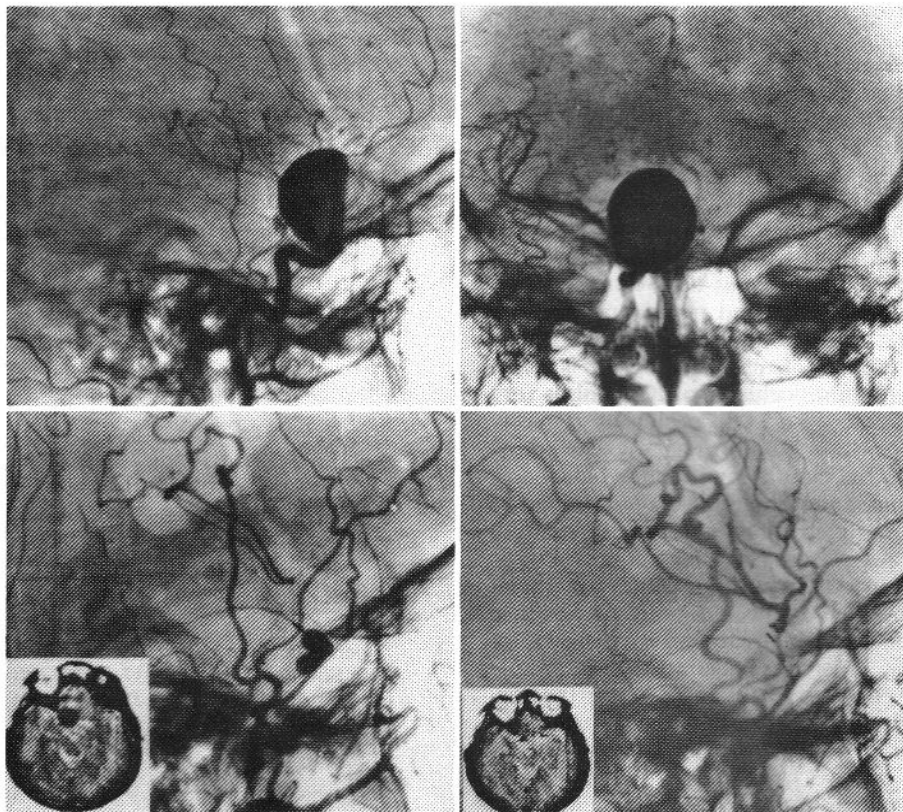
Case 2. *Upper Pair:* Angiograms before internal carotid artery occlusion and extracranial-intracranial bypass showing a giant partially thrombosed carotid-ophthalmic artery aneurysm. *Lower Left:* The size of the aneurysm is better appreciated on the computerized tomography (CT) scan (*inset*). The intraoperative angiographic control showed good bypass patency and no filling of the aneurysm. Note the balloon *in situ* is still filled with contrast material. *Lower Right:* One year after operation, the CT scan (*inset*) and angiogram show the virtual disappearance of the lesion. The bypass is functioning extremely well.
